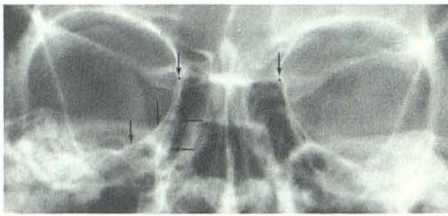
Caldwell (inclined posteroanterior) view of skull. Lamina papyracea of ethmoid is demonstrated by two lines on each side. Horizontal arrows point to anterior part of lamina papyracea and lower vertical arrows point to posterior part of it. Upper vertical arrows point to black dots, which indicate points at which usually interorbital distance is measured on radiograph. (Reprinted from [3].)
